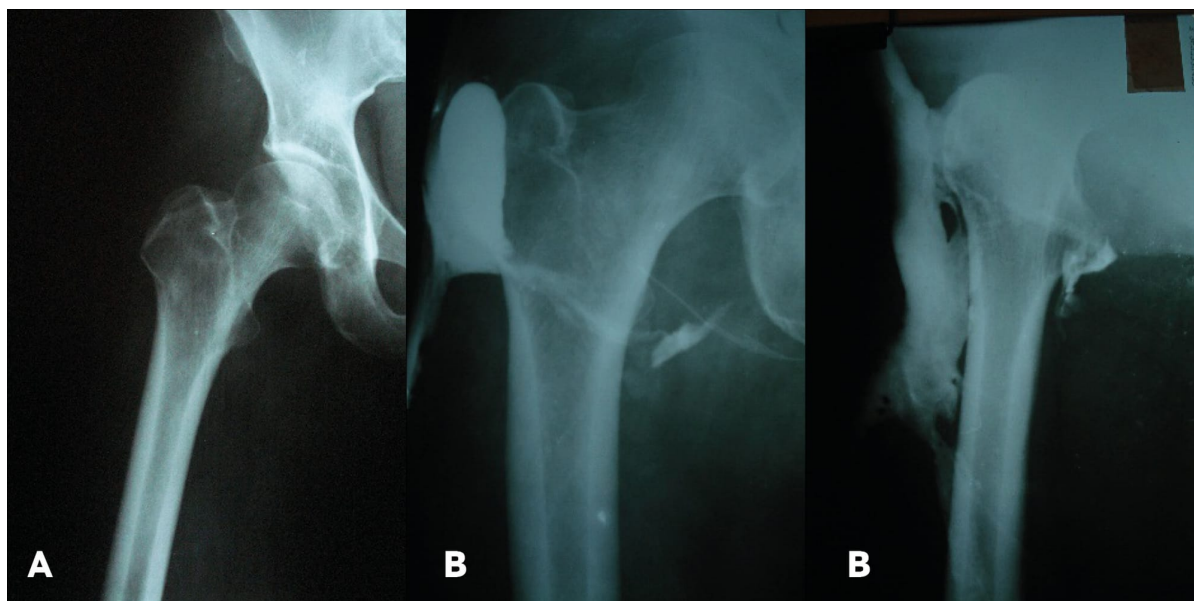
X-ray images of patient D. A — upon admission, B — fistulograms.
